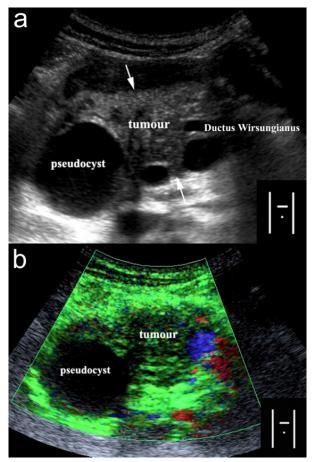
Pancreatitis-associated lesion at conventional (a.) and echo-enhanced sonography (b.). a. Lobulated mass (arrows) with a small pseudocyst. b. Highly vascularized lesion compared to the surrounding tissue.
